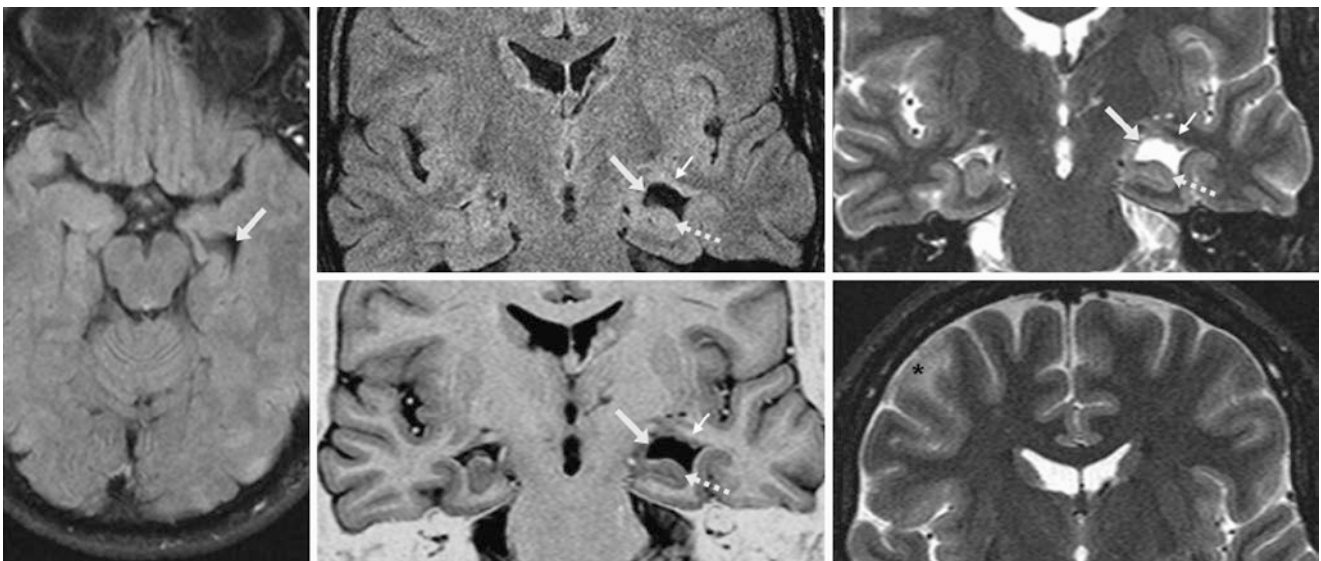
Comparison case of tuberous sclerosis. A 33 year old with seizures had enlargement of the left temporal horn (arrows) on axial FLAIR MRI (left). Coronal FLAIR (top middle), coronal T1WI-IR (bottom middle), and coronal T2WI (top right) demonstrated abnormally thickened tissue (tiny arrows), indicating dysplastic tissue within
